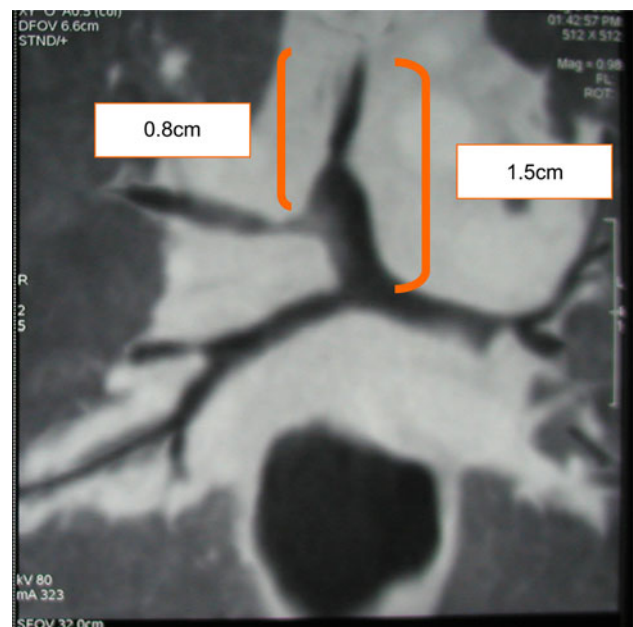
3D-CT findings. Tracheal branching from the esophagus was narrowed at the superior portion. The tracheal bifurcation was 1.5 cm from the fistula. The right upper lobe bronchus arose in an area 0.8 cm from the fistula and formed a tracheal bronchus
